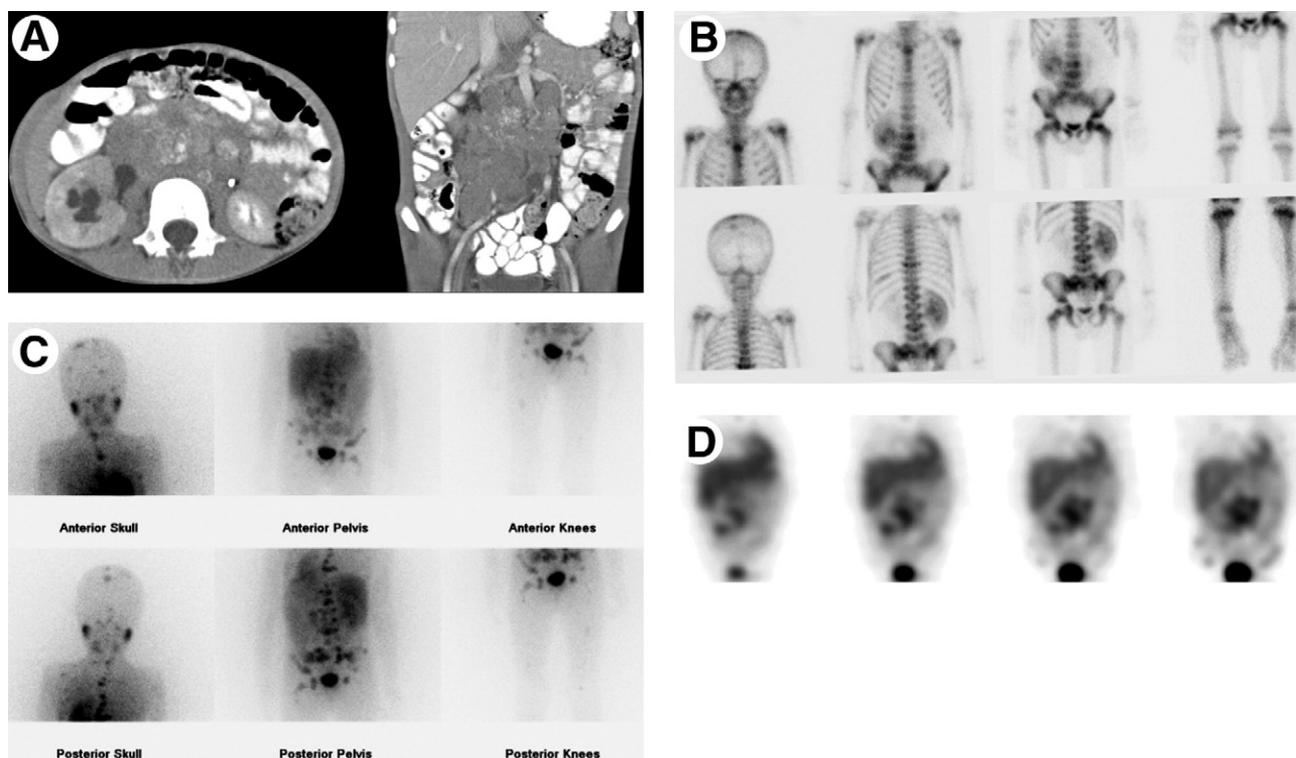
The abdominal examination in a 5-year-old boy revealed a large mass which on CT (A: transaxial, coronal) shows a large solid calcified mass in the midabdomen, causing obstruction to the right kidney, encasing the main intra-abdominal vessels and with focal areas of calcification. A total body bone scan (B) shows multiple skeletal metastases. The ^{123}I -MIBG study shows multiple focal osteomedullary metastases (C). There is heterogeneous uptake in the primary tumor consistent with necrosis. This was more obvious on the SPECT study (coronal; D).
